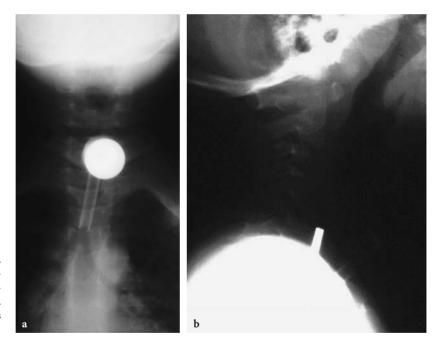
Two impacted coins. a The AP view of the airway is confusing. The metallic density resembles part of the tracheostomy tube. b The lateral radiograph reveals two coins in the esophagus
